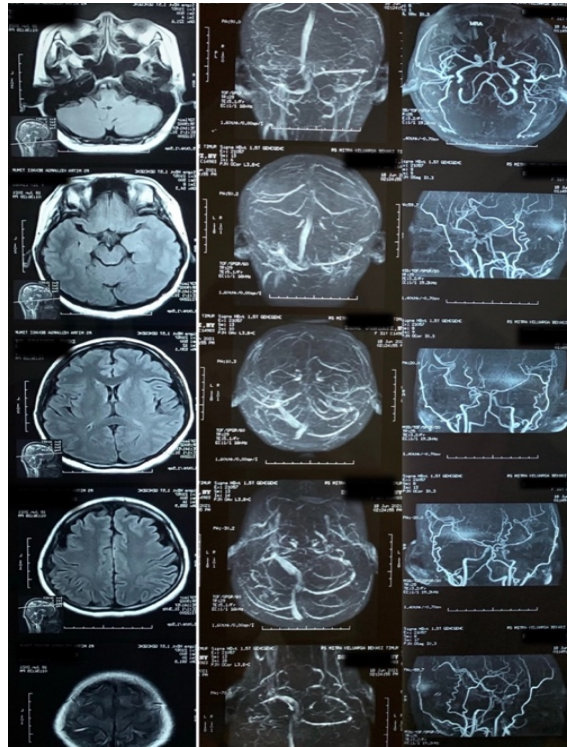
Compression and ischemic lesions were absent on MRA, MRI, and MRV.
